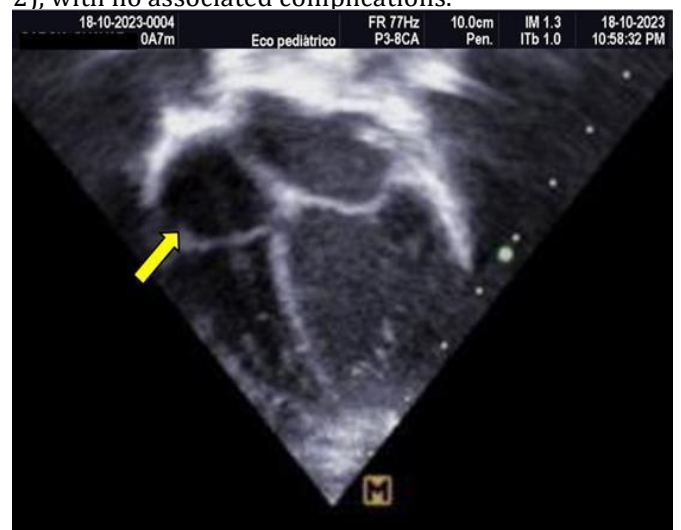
Transthoracic Echocardiogram, Apical 4-Chamber View: Complete resolution of the interatrial thrombus.
